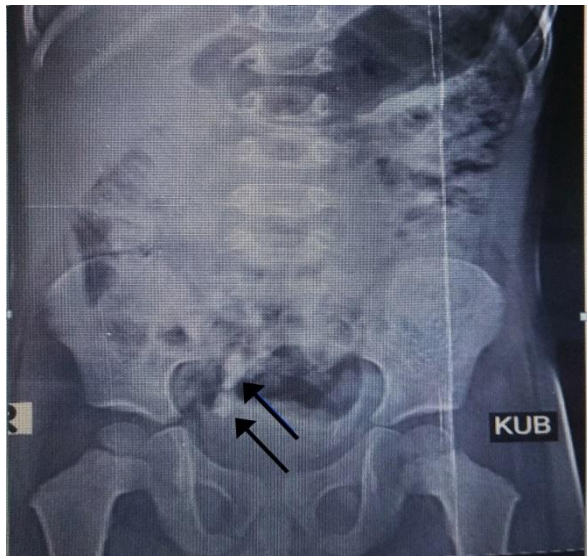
Plain X-ray KUB region showing two radiopaque shadows in right pelvis
